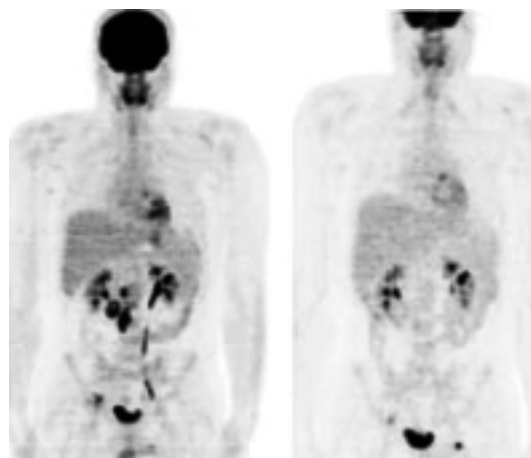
A germ-cell tumor with clear abdominal lymph node FDG-avid disease.
